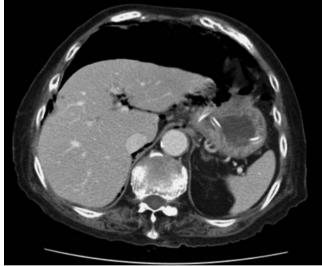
Abdominal computed tomography (CT) revealed pneumoperitoneum.
